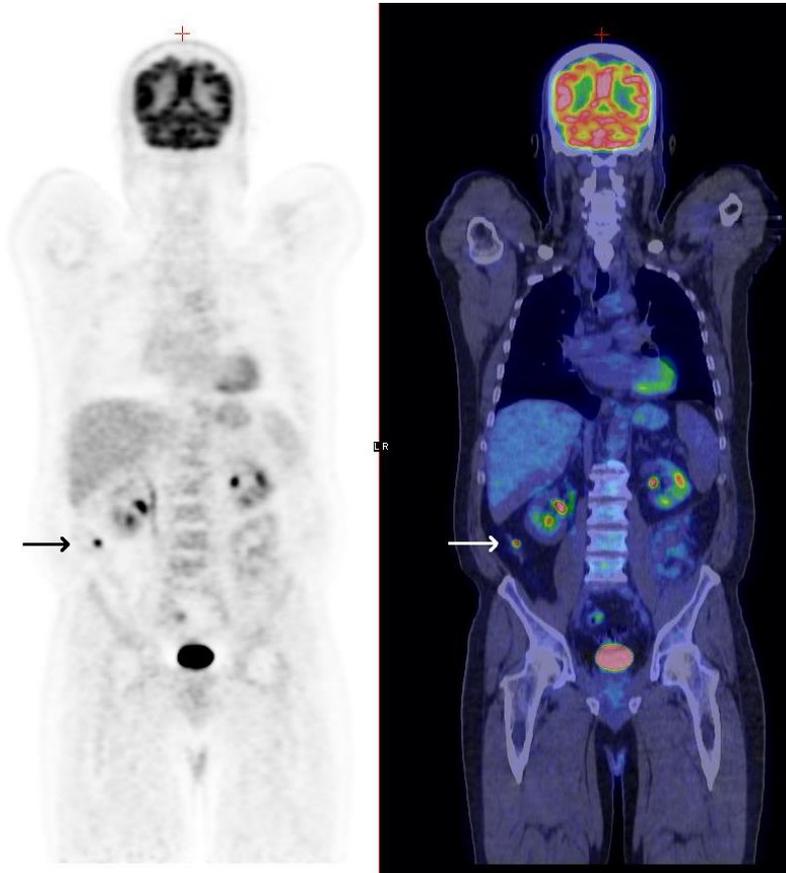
Coronal plane PET scan demonstrating FDG avid appendix (arrows)
